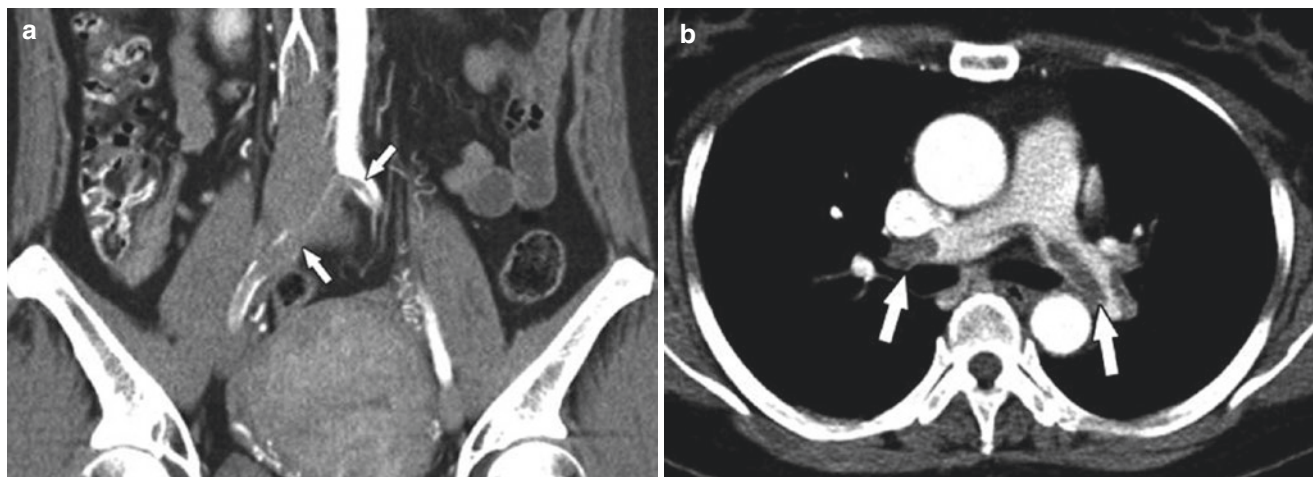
(a) CT angiogram reveals a saddle embolism at the aortic bifurcation. (b) CT angiogram of the chest reveals large bilateral pulmonary emboli
